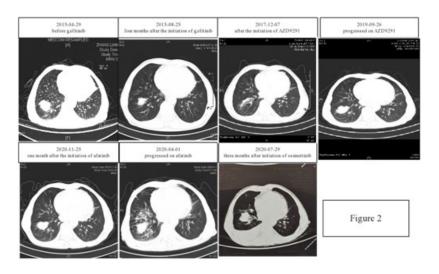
Computed tomography (CT) scans are ordered according to the time point relative to the treatment.
